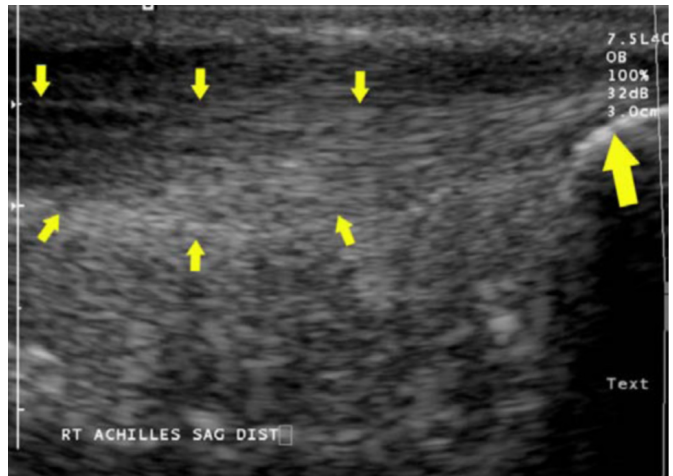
Sagittal sonographic view of right distal Achilles tendon, showing focal thickening (small arrows) slightly proximal to the calcaneal insertion (large arrow).
